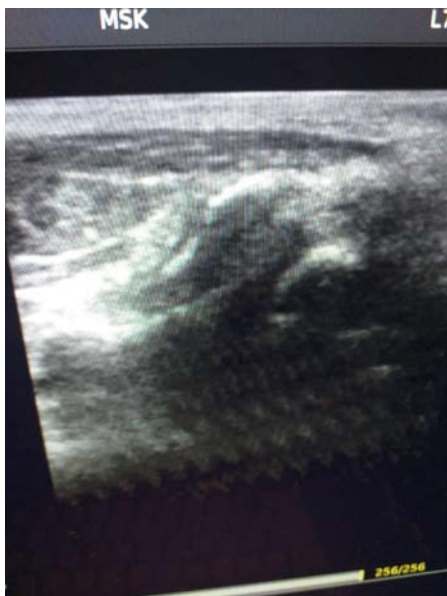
Ultrasound scan of the right hand
